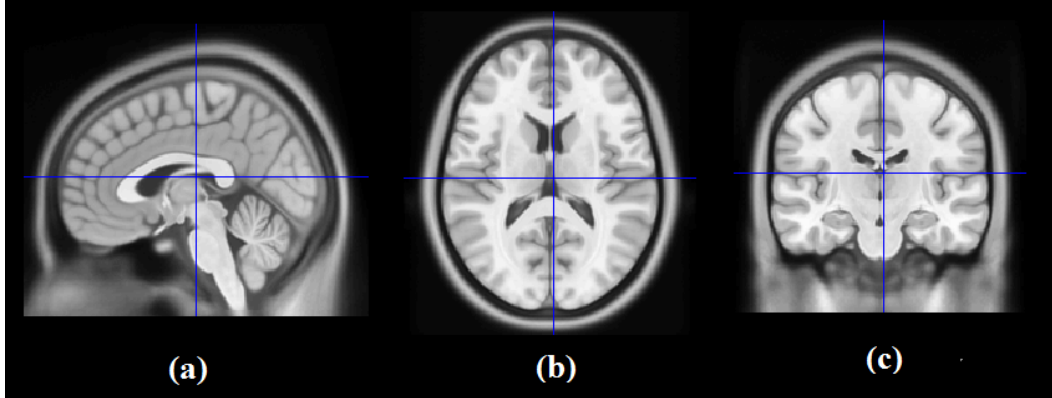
T1-weighted MRI images in: (a) sagittal, (b) axial, and (c) coronal view of the ICBM 152 brain atlas.
